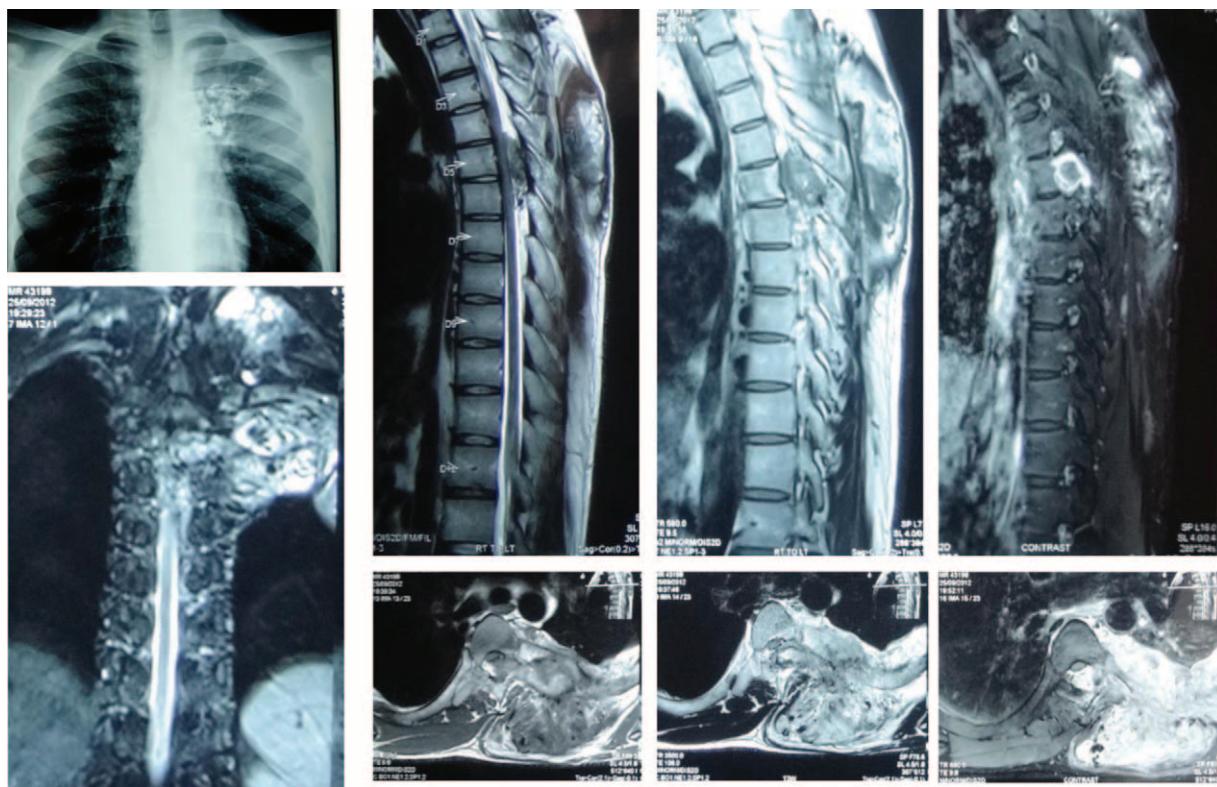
HRCT revealed a large vascular malformation with feeding arteries, draining veins on extra pleural space on the left side. Large vascular channels seen in the epidural space compressing the cord. There is expansion and destruction of left fifth and sixth rib on the left. A, Large plaque-like lesion in left hemithorax with destruction of underlying rib and posterior element of D5 vertebra. Extension of the lesion in the left lateral and posterior epidural space causing significant cord compression (B and C).
